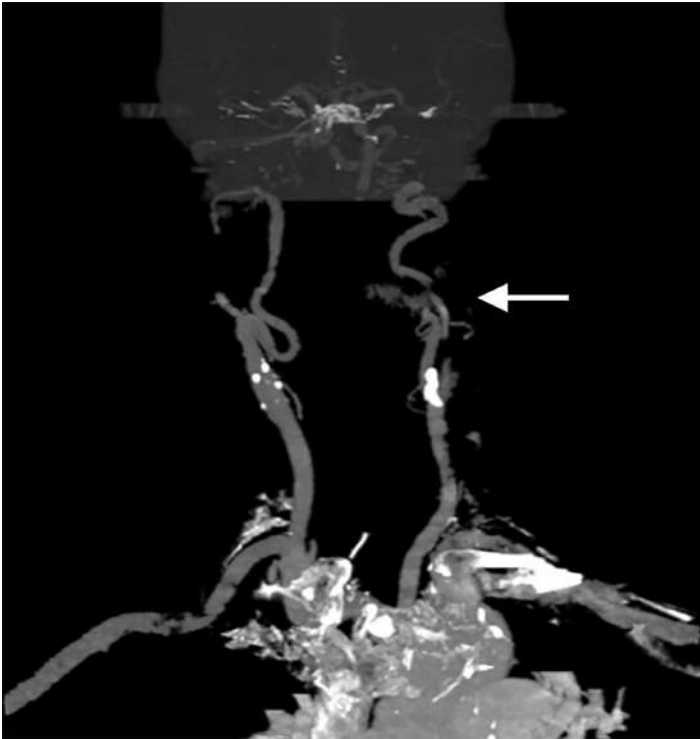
Coronal view of computed tomography with angiography of the head and neck identifying an irregular 50-60% narrowing of proximal mid-cervical segment of left internal carotid artery with intimal flap consistent with carotid artery dissection.
